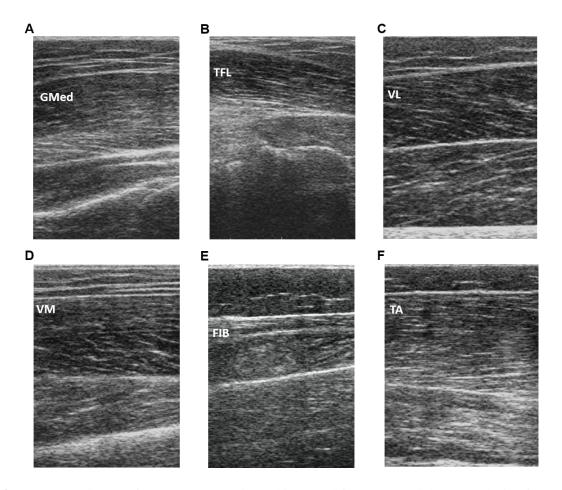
Ultrasound images from a representative subject used for muscle thickness analysis of GMed (A), TFL (B), VL (C), VM (D), FIB (E) and TA (F).
